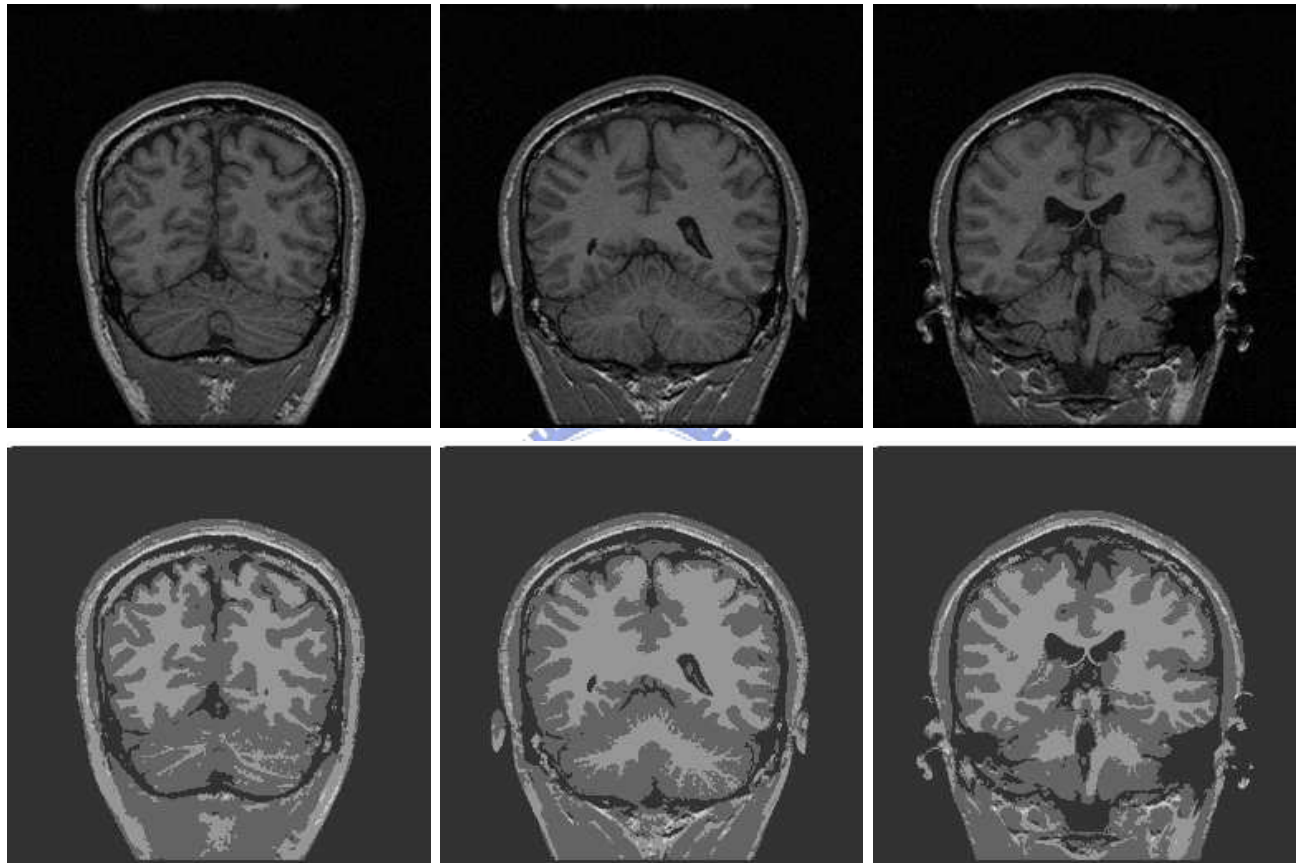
The pixels in the MR images are partitioned into 4 sets. From left to right, each column shows the original image (above) and the processed image (below).
